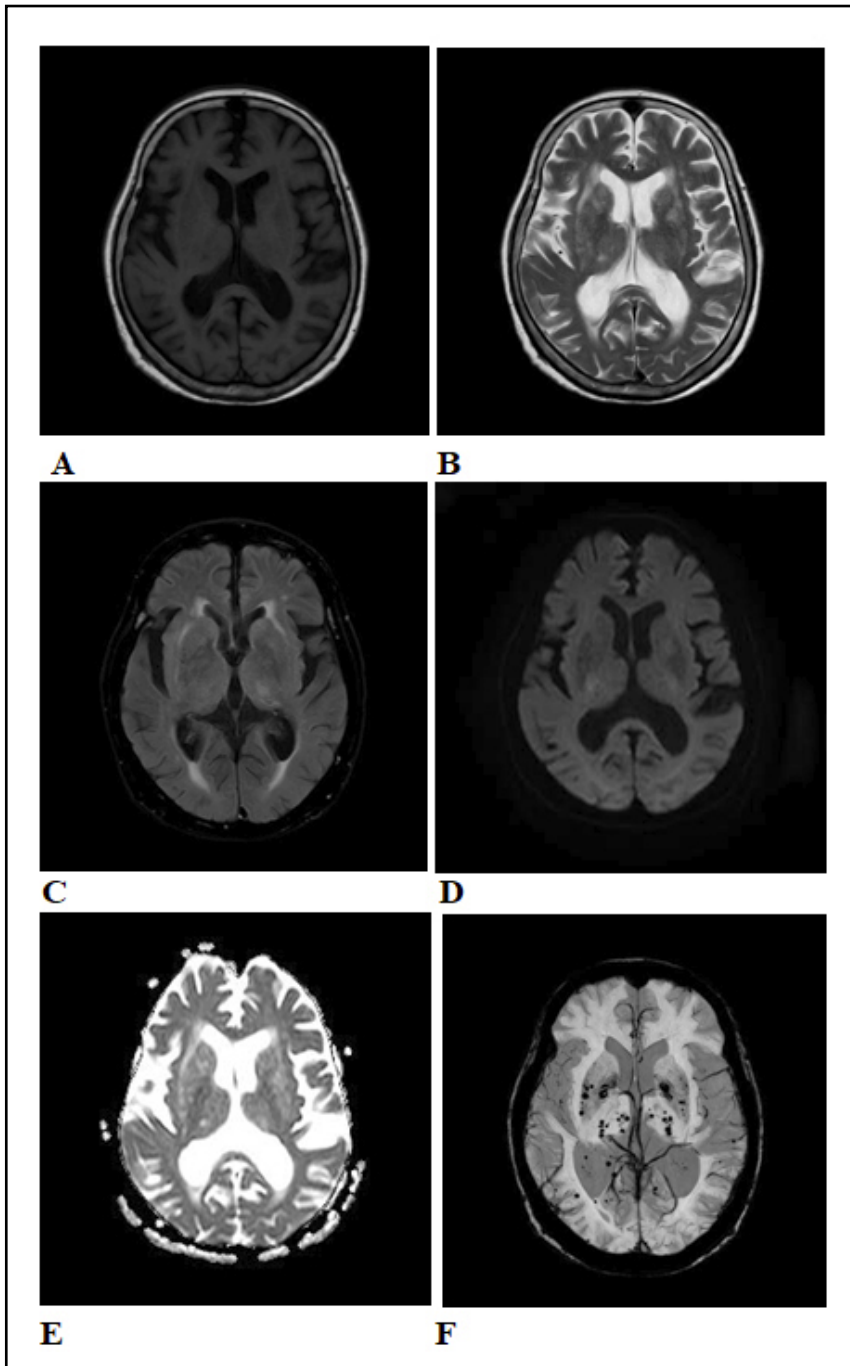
A,B,C,D,E,F: magnetic resonance imaging showed no diffusion-limited signal in the diffusion-weighted imaging sequence.
